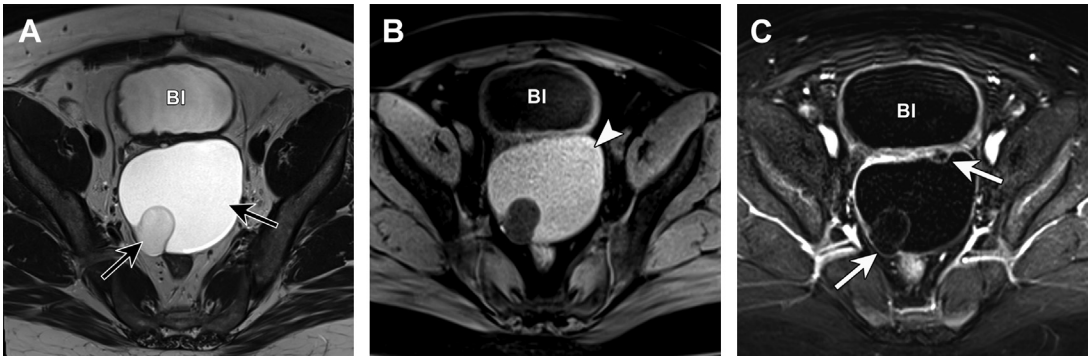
Mucinous cystadenoma of the right ovary which is located posterior to the bladder. Axial T2-weighted MR image (A) shows a multilocular cystic mass with differing signal intensity within different locules (*black arrows*). Axial T1-weighted MR image with fat saturation (B) shows homogenous hyperintense signal in one of the locules due to variation in mucin content (*white arrowhead*). Axial post-contrast T1-weighted image with fat saturation (C) shows thin enhancing septations (*white arrows*) and no enhancing solid components. BI, bladder.
